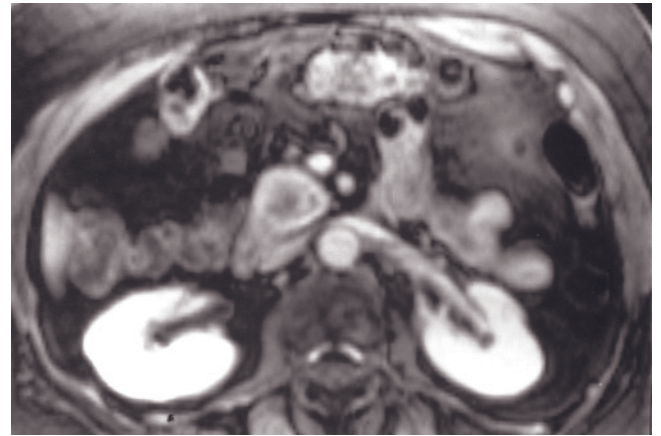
Pancreatic cancer arising in the head. T2-weighted echo-train spin-echo (a), T1-weighted SGE (b), T1-weighted fat-suppressed SGE (c), immediate postgadolinium T1-weighted SGE (d), and 90-s postgadolinium fat-suppressed SGE (e) images. There is a 4-cm tumor arising in the pancreatic head, which appears hypointense on T1 (b, c)- and T2 (a)-weighted images. On immediate postgadolinium images (c), the tumor exhibits diminished enhancement compared to normal adjacent pancreatic parenchyma, with demarcation of the tumor edges (arrow, d) with background pancreas.
